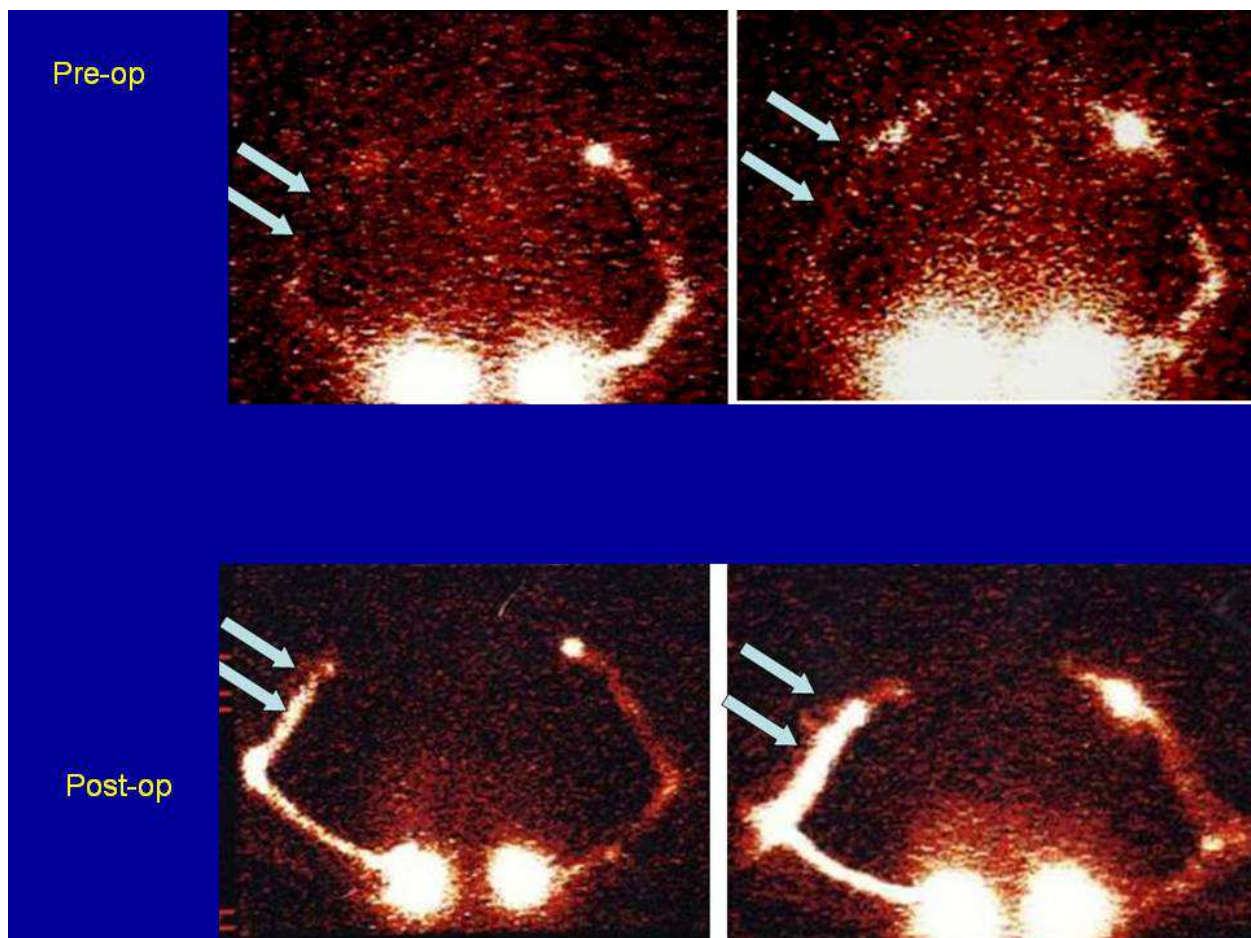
Lymphoscintigraphic patterns before and after axillary lymphnodal dissection associated with LYMPHA technique.
